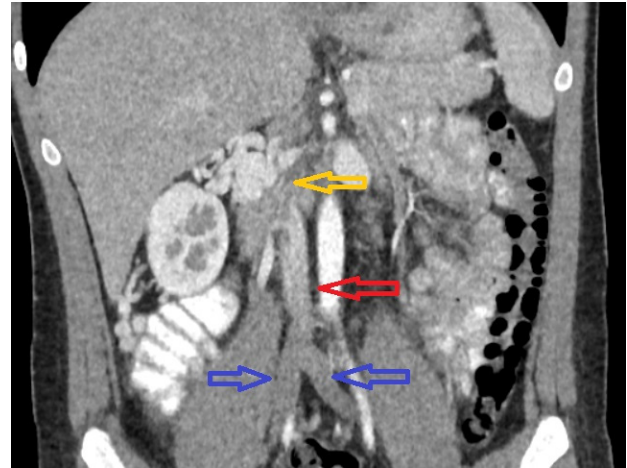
Coronal view of CT scan of IVCA showing continuation of IVC after the renal hilum (yellow arrow), continuation of infrarenal IVC (red arrow) and bifurcation of bilateral iliac vein (blue arrow)
